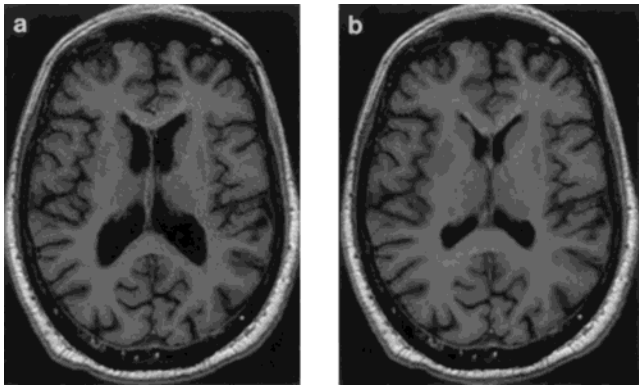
An MR image from an individual with relatively large ventricles (a) and its transformation after applying a uniform stress within the ventricles (b).
